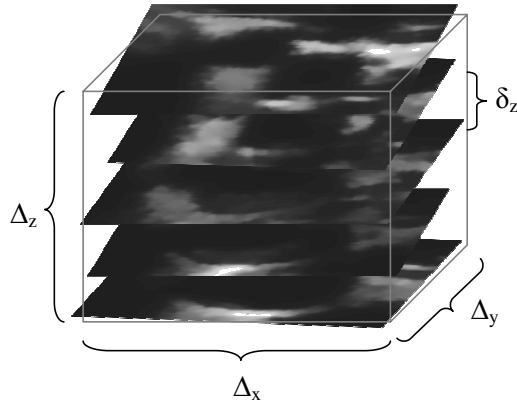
Sequence of cross-sections used for 3D ultrasound (Dimensions of the region of interest are also indicated).
